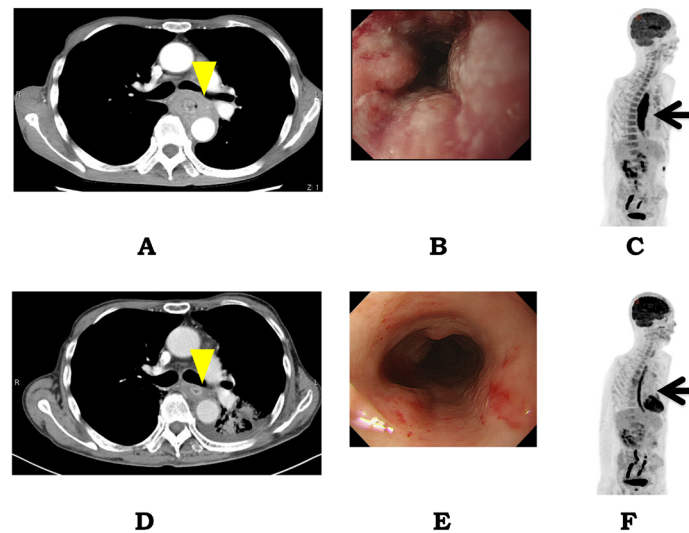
A case of clinical T4 esophageal squamous cell carcinoma (ESCC) in pre-treatment status (A-C) and status after definitive chemoradiation therapy (dCRT) (D-F). (A) CT imaging of left bronchial level; (B) Endoscopic film of esophageal cancer; (C) ^{18}F -fluorodeoxyglucose-positron emission tomography (FDG-PET) scan of esophageal cancer; (D) CT imaging of left bronchial level; (E) Endoscopic film of esophageal cancer; (F) FDG-PET scan after dCRT.
